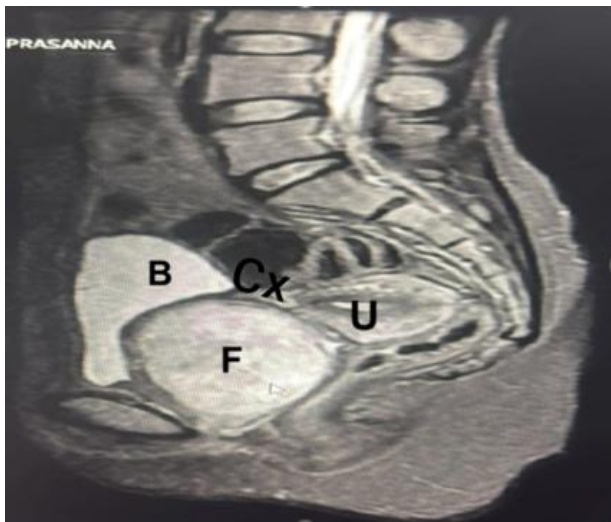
MRI showing a well-defined lesion ($5.1 \times 6.8 \times 7.3$ cm) suggestive of anterior vaginal fibroid (F). B - Urinary bladder; Cx - Cervix; U - Uterus
